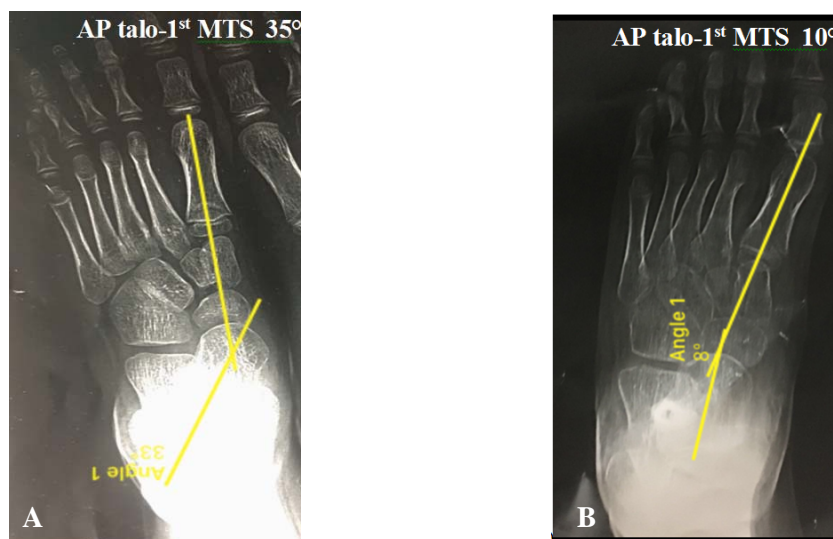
Radiographs showing measurement of preop. (A) and postop. (B) AP talo 1st-MTS angles.
